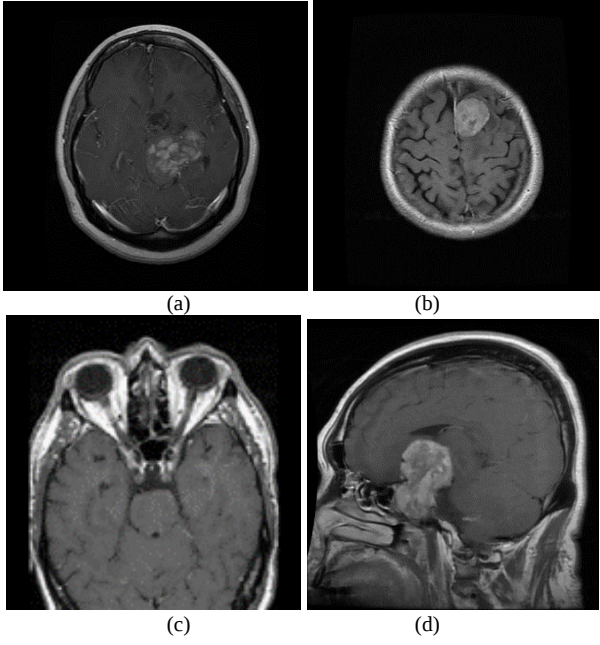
MRI Scans of BT.
